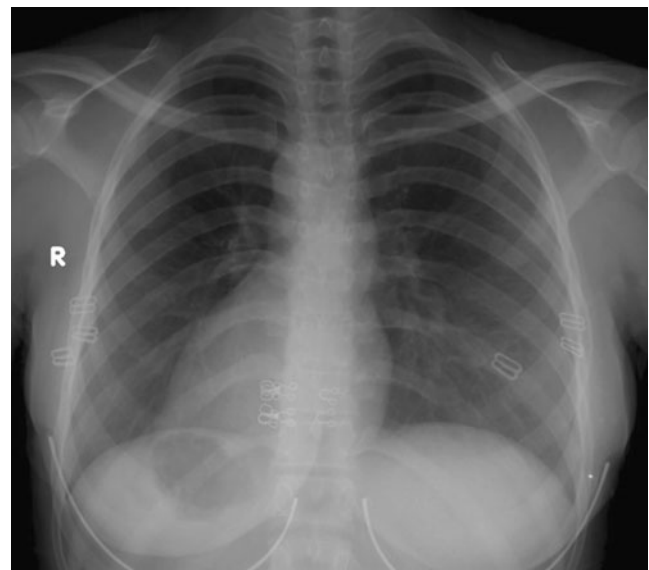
X-ray of chest PA view. The apex of cardiac shadow is on the right side.
